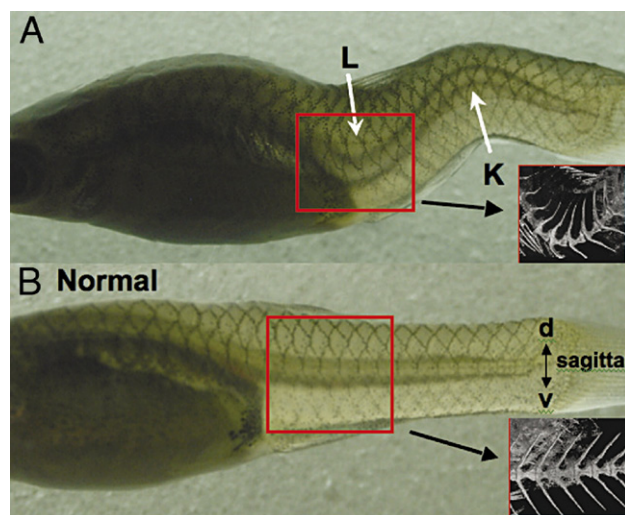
A: The *curveback* phenotype is a primary anterior lordosis (L) and a secondary posterior kyphosis (K) occurring on the sagittal plane. CT scan shows no vertebral breaks or fusion associated with curvature (some individuals demonstrate coronal deviation—not shown). B: Normal fish with sagittal plane and dorsal/ventral axes shown. Digital photos of anaesthetized adult females taken on a standard light table under 3X magnification, CT scans consist of 350 0.4 mm slices. Images taken at the University of Texas High-Resolution X-ray CT Facility, (datasets of scans available for view at <http://www.digimorph.org/index.phtml>).
